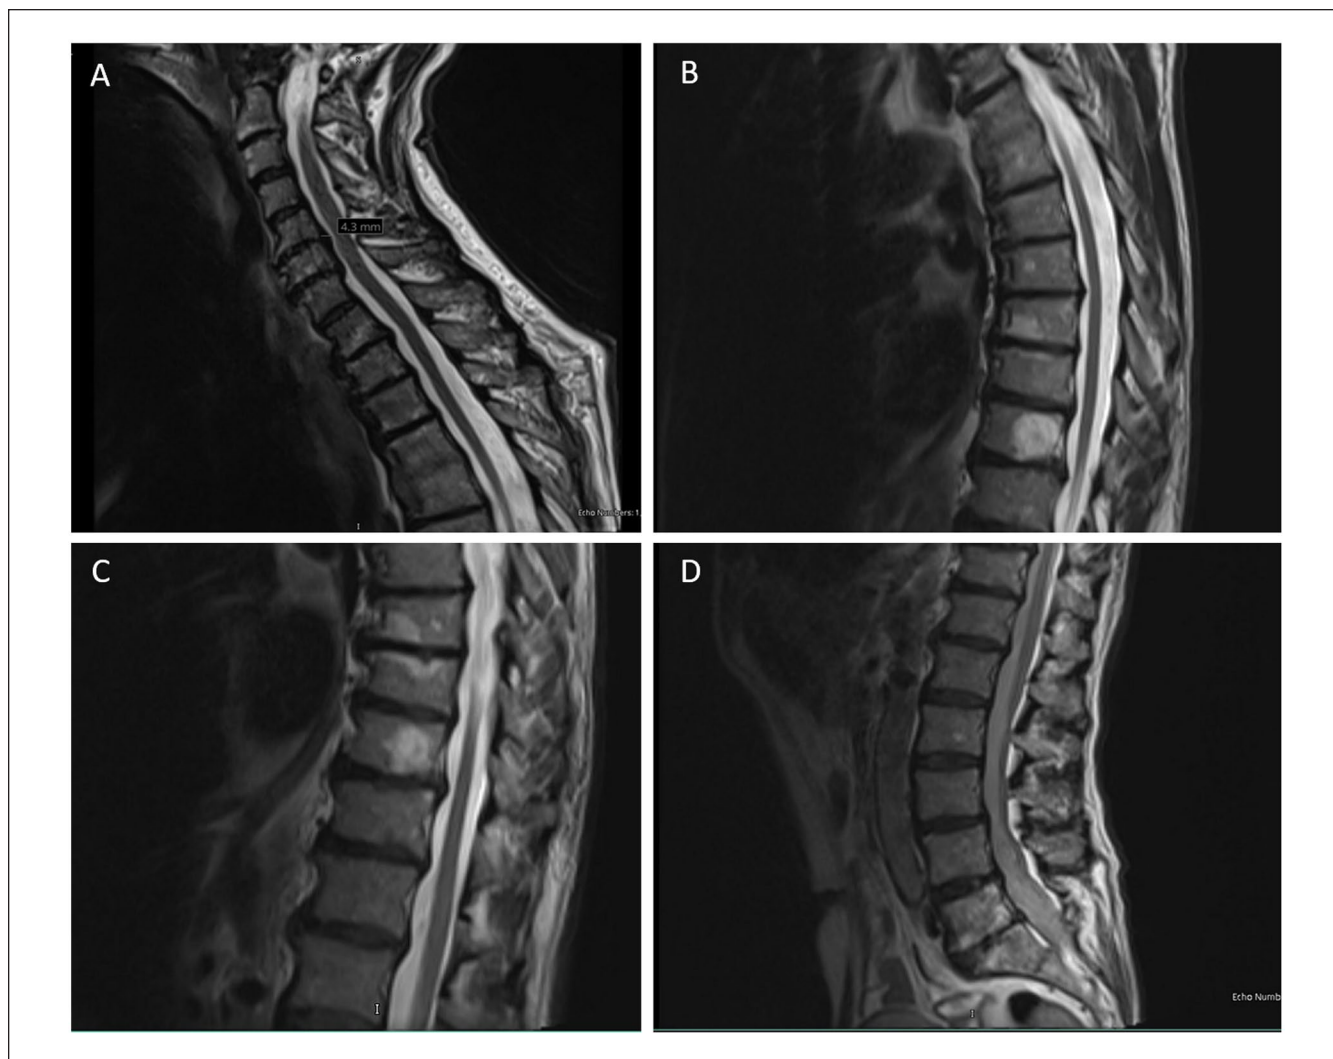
Cervical (panel A), thoracic (panels B and C), and lumbar (panel D) spine MRI imaging reported advanced multilevel degenerative disk and facet changes, C5-6 and C6-7 spinal canal stenosis, T4 and T5 vertebral body fusion, and posterior disk osteophyte complex at T7-8. There was no abnormal signal change in the spinal cord.
